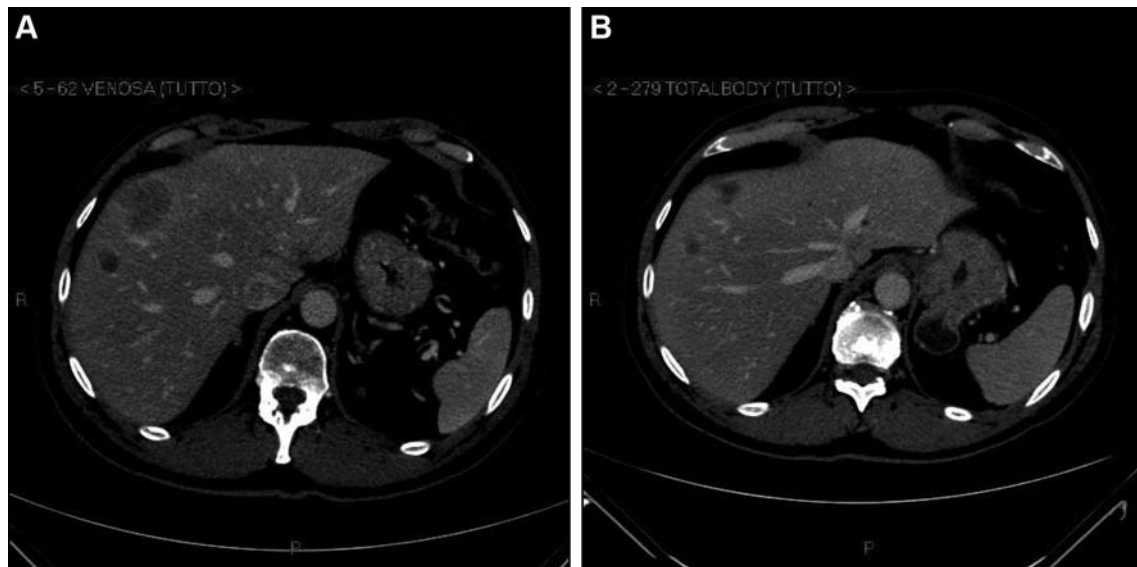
Magnetic resonance image of (MRI) of multiple liver metastases from uveal melanoma. A, MRI before TACE; B, MRI 3 months after TACE.
